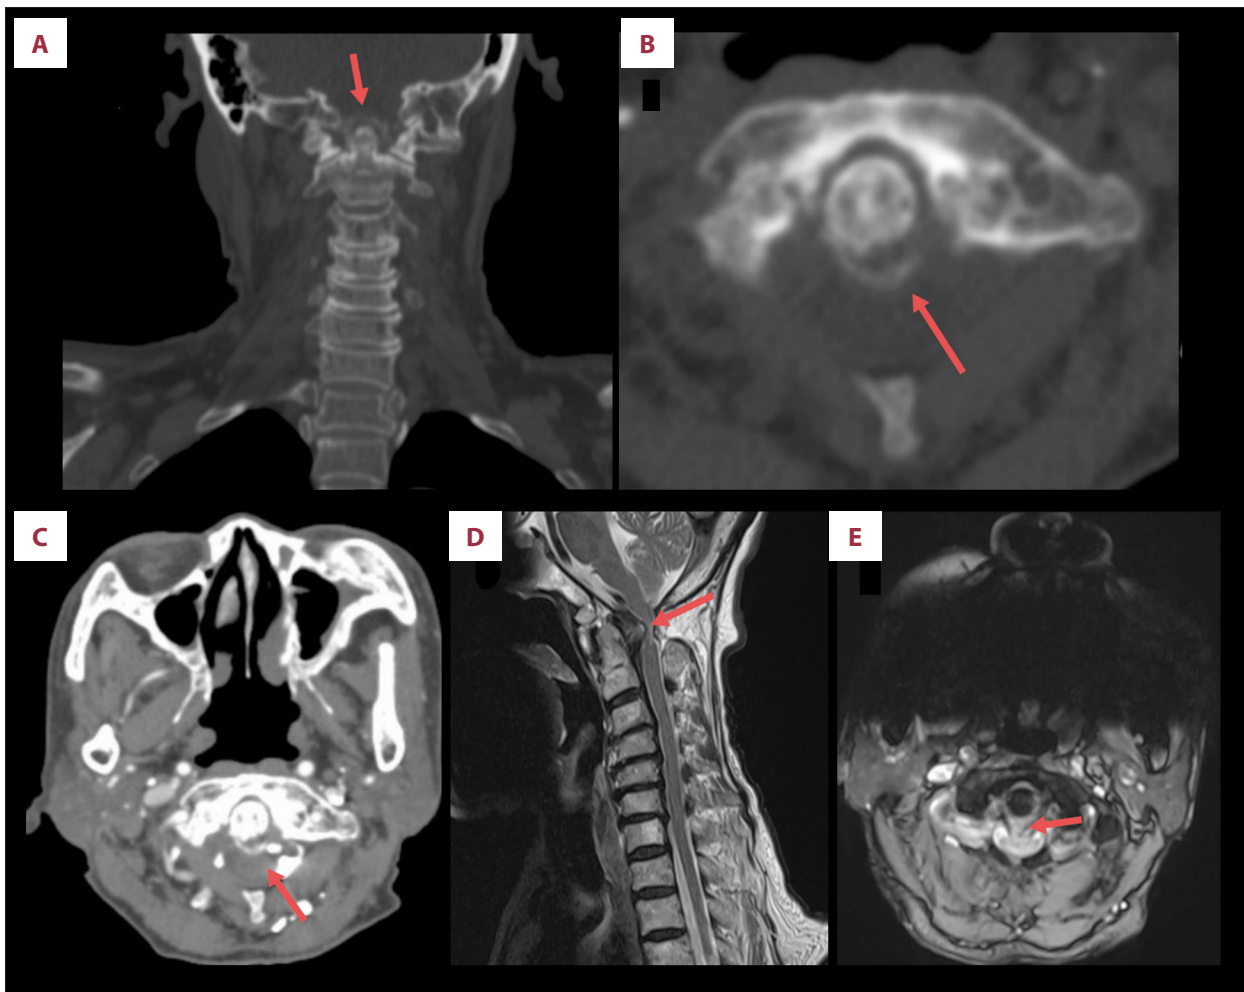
(A) Coronal computed tomography (CT) scan showing transverse ligament calcification around the odontoid process. (B) Axial CT scan (bone window) confirming calcification. (C) Axial CT scan (soft-tissue window) demonstrating the same finding. (D) Sagittal magnetic resonance imaging (MRI) revealing transverse and alar ligament calcification compressing the medulla oblongata. (E) Axial MRI confirming ligament calcification with medullary compression.
